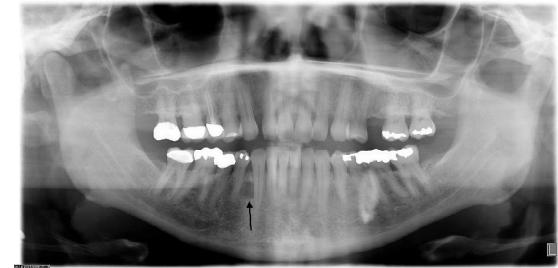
Orthopantomograph showing radiolucent area between #27-28 (arrow).
